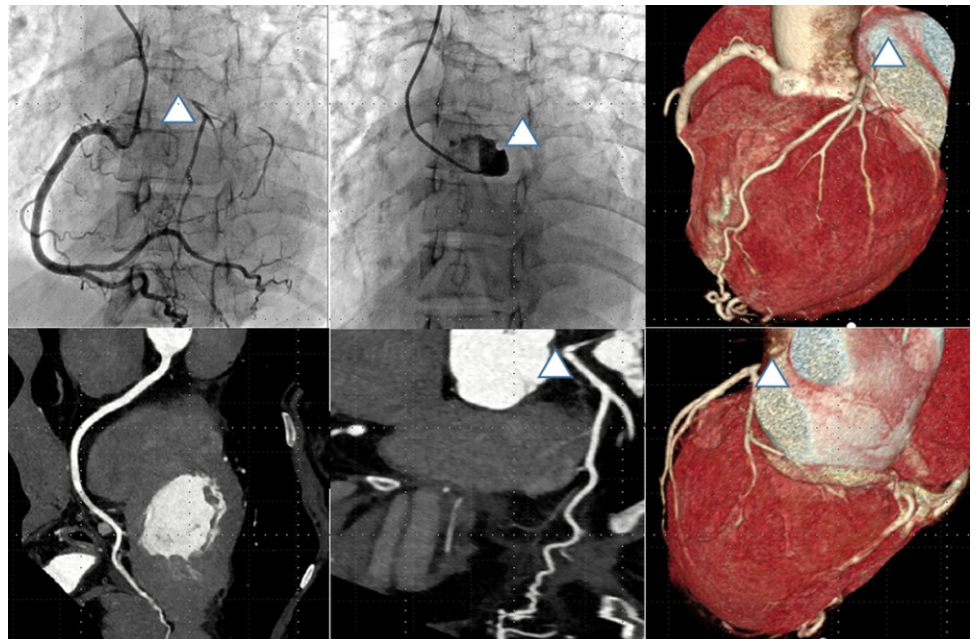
CT angiography and invasive angiography for coronary. triangle showed the occlusion.
